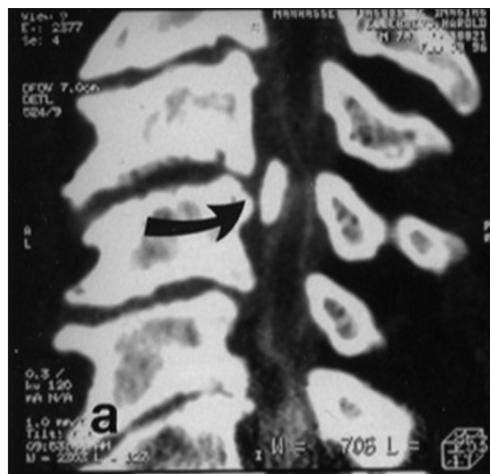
Midline sagittal Myelo-CT documenting early OPLL compressing the cord at the C3-C4 and C4-C5 Levels. Patient with marked cord compression due to early OPLL are also extremely susceptible to CSS injury following even minor hyperextension trauma. Early OPLL is defined by hypertrophied posterior longitudinal ligament (HPLL) combined with progressive punctate ossification centers. In this midline sagittal Myelo-CT study, marked ventral compression at the C3-C4 level is attribute to a coalescence of punctate ossification centers within HPLL (e.g., pearl of ossification). At the C4-C5 level below, HPLL itself without such ossification contributes to marked cord compromise
